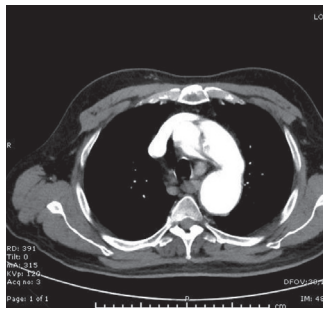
Cranial CT angiography scan showing a dissection of arcus aorta.
